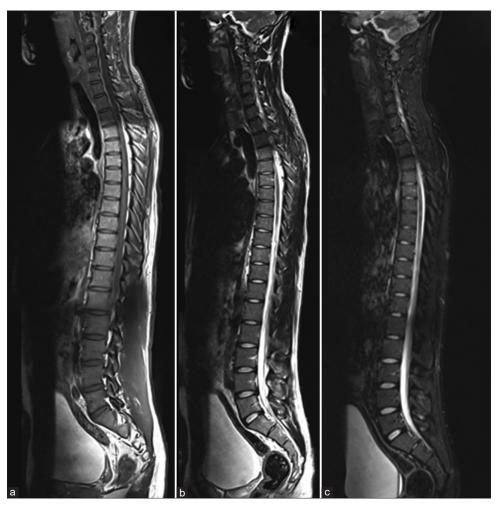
A 23-year-old male with chronic progressive external ophthalmoplegia plus. Findings: There is a loss of normal cervical lordosis. The brainstem, spinal cord, vertebral height, disc height, alignment, and bone marrow signal are within normal limits. The canal and neural exit foramina are capacious at all levels. The conus terminates at the T12/L1 level and is normal in appearance. Techniques: Total spine magnetic resonance imaging images, all are sagittal planes: (a) T1W noncontrasted, (b) T2W, and (c) Short tau inversion recovery
